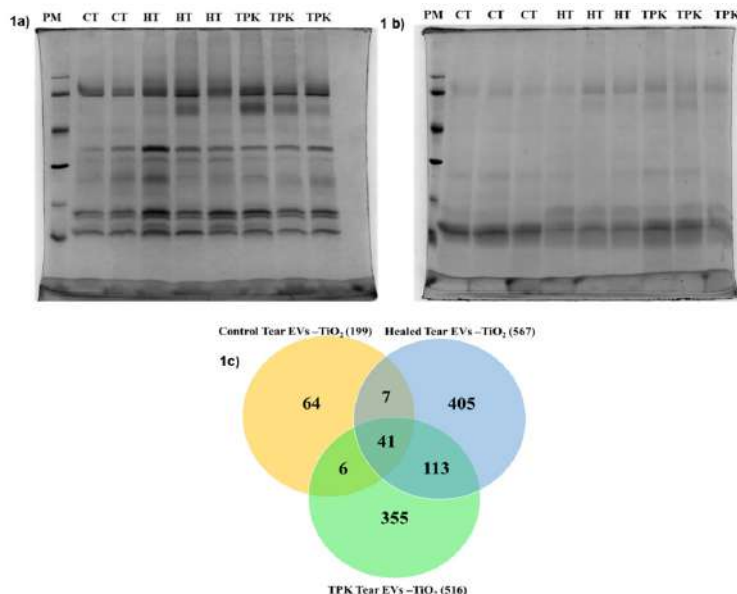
a) The 1D gel electrophoresis of tear protein from control tear (CT), Keratitis patient tear Healed Tear (HT) and Keratitis patient tear from Non responder tear (TPK), b) The 1D gel electrophoresis of Tear EV protein profile prepared by TiO_2 method from control tear (CT), Keratitis patient tear Healed Tear (HT) and (TPK), c) Number of protein identified through In gel digestion (Shotgun) from Tear EVs prepared by TiO_2 method.
